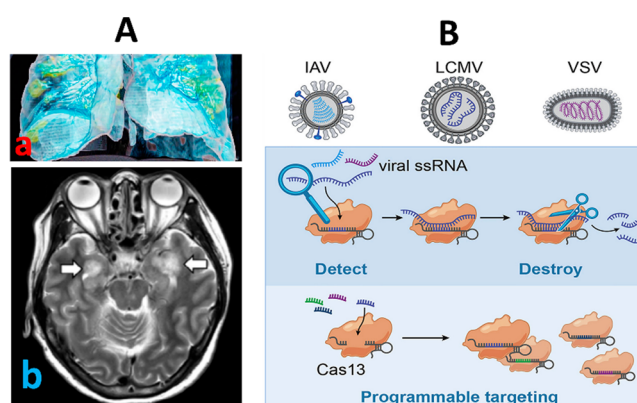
(A) Lung and brain damage from SARS-CoV-2 [SARS-CoV-2 caused extensive damage (yellow, as predicted 3D modeling using a computerized tomography scans) on the lungs of a 59-year-old man who died due to disease severity (a) and MRI images analysis of a 58-year-old woman with COVID-19 showed encephalitis which causes brain tissue damage (b)]. Reprinted with permission from ref 39. Copyright 2020 American Association for the Advancement of Science. (B) CRISPR Cas9-based gene-edited strategy proposed to recognize and eradicate mutated genome. This approach can be useful for selective detection and diagnostics of COVID-19. Reprinted with permission from ref 45. Copyright 2020 Elsevier.
